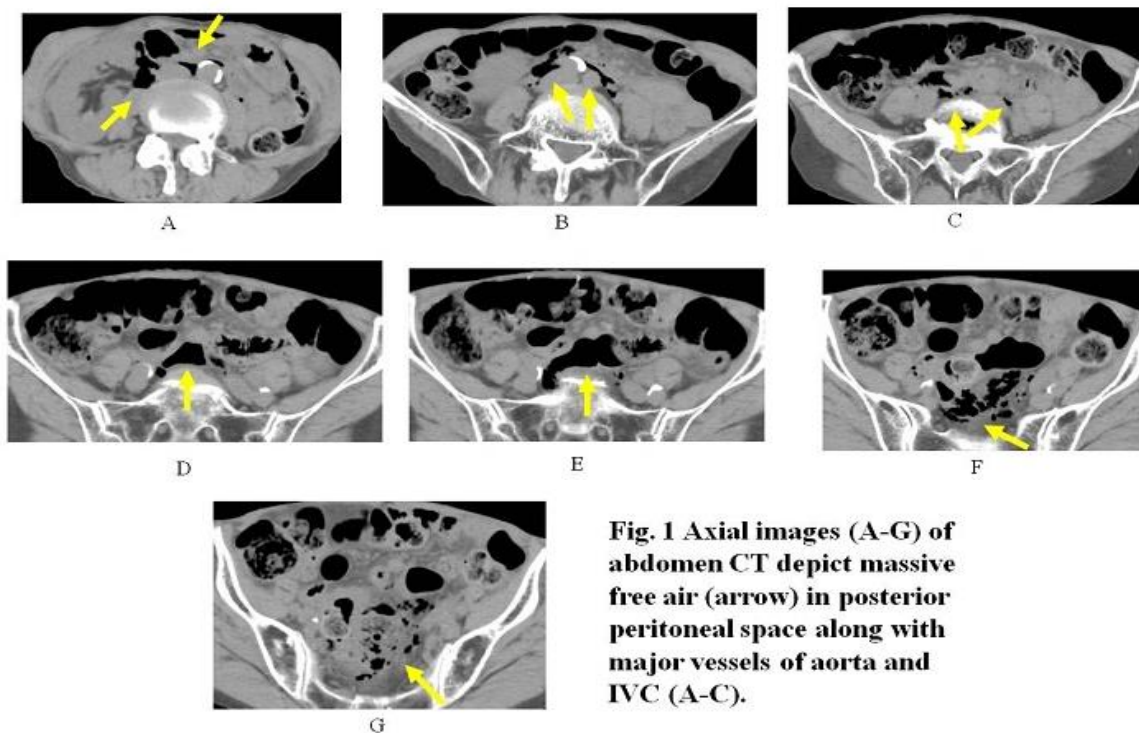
Axial images (A-G) of abdomen CT depict massive free air (arrow) in posterior peritoneal space along with major vessels of aorta and IVC (A-C).
